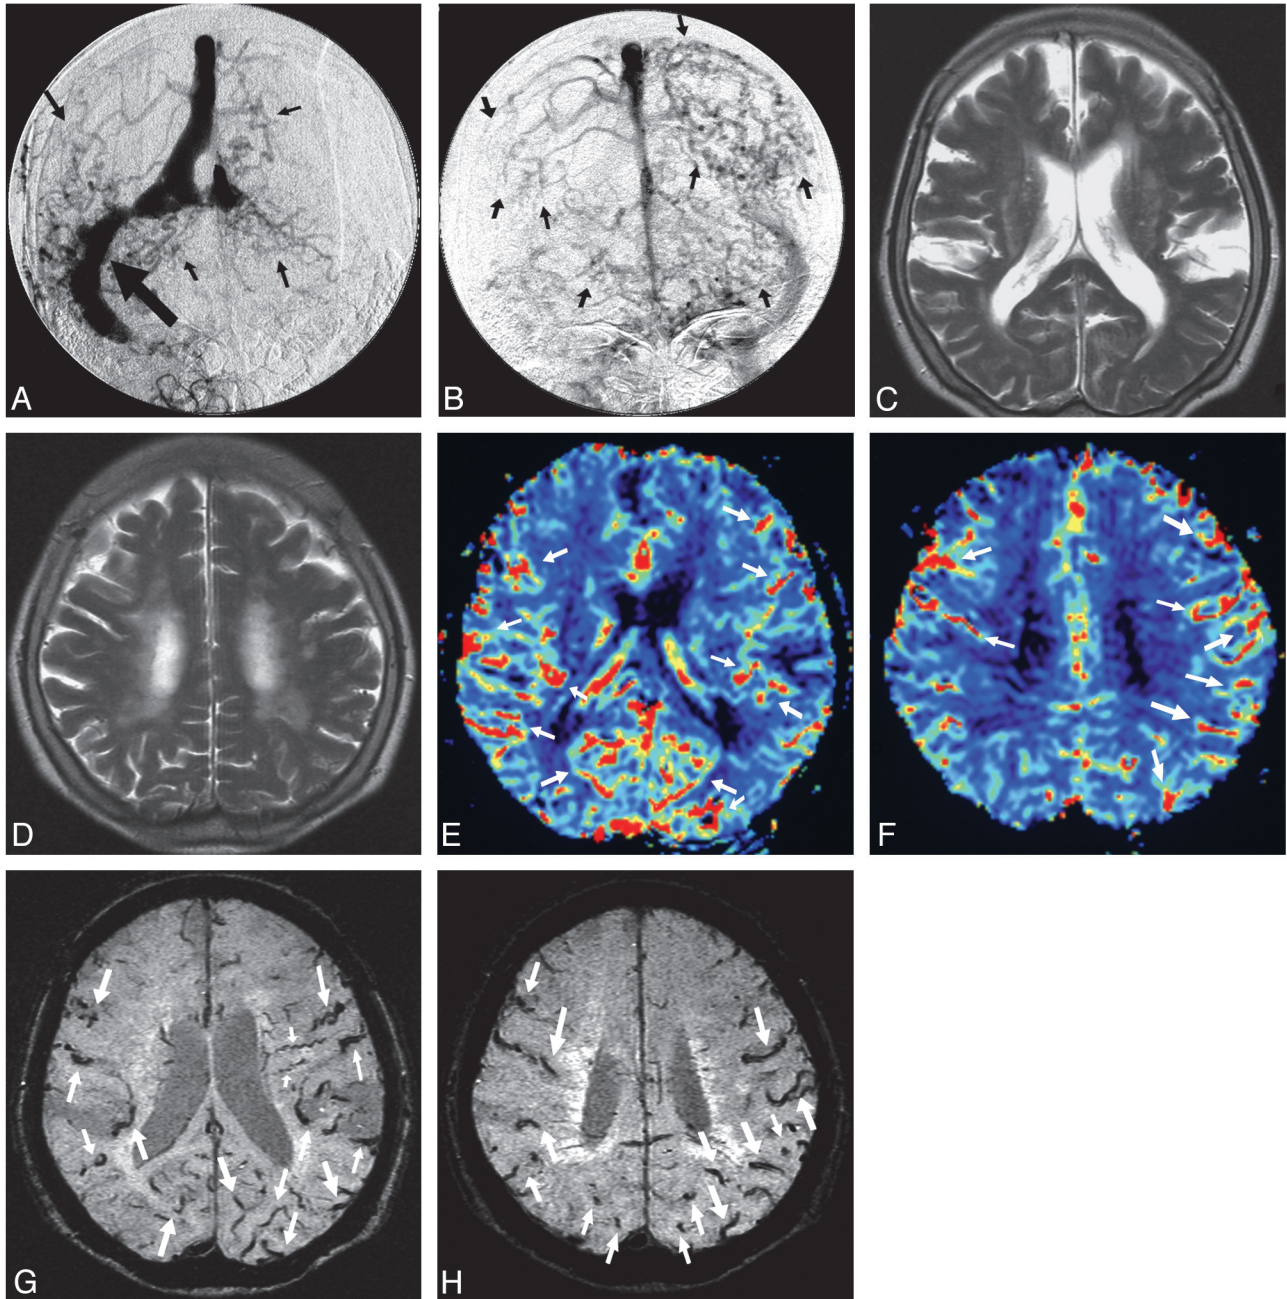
DAVF at the right TSS with both hemispheres affected in a 77-year-old woman (case 7). *A*, Arterial phase of a right external carotid angiogram shows a DAVF at the right TSS (*large arrow*) with retrograde venous drainage into the superior sagittal sinus and bilateral cortical veins (*small arrows*), with occlusions of the distal portion of right sigmoid sinus and of the proximal portion of left transverse sinus. *B*, Venous phase of a right external carotid angiogram shows marked venous congestion (*arrows*) in both hemispheres. *C* and *D*, T2-weighted image shows no abnormal flow-voids. *E* and *F*, DSC shows increased cerebral blood volume in both hemispheres (*arrows*). *G* and *H*, SWI shows dilation of cortical veins (*large arrows*) in both hemispheres and dilation of medullary veins (*small arrows*) in the left hemisphere.
